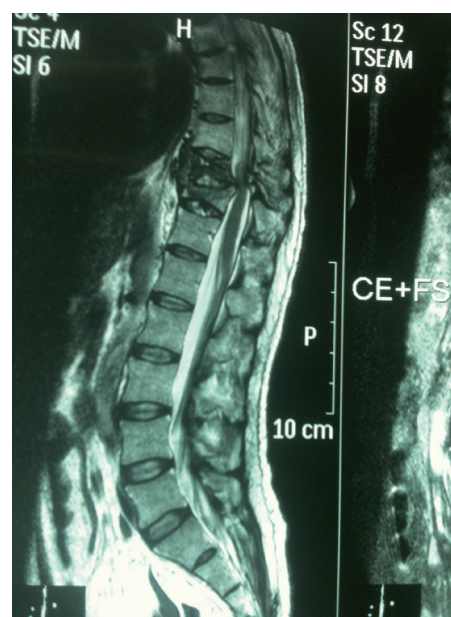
Magnetic resonance imaging of dorsolumbar spine showing a central collapse of DV₁₀ and DV₁₁ and anterior wedging of DV₇ and DV₉ causing an indentation upon the thecal sac and compression on the cord.
